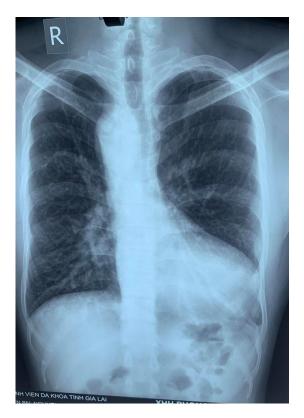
Chest x-ray showed right side aortic arch with increased pulmonary vascularity
